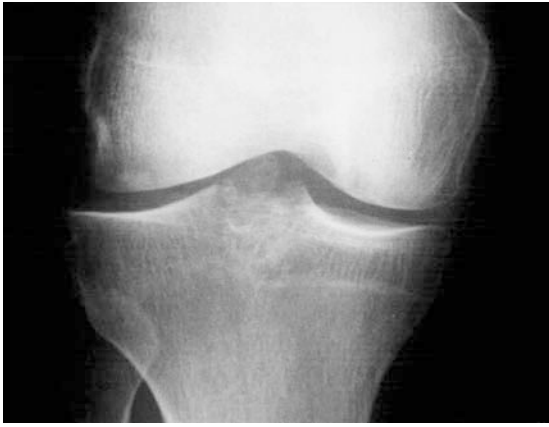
Plain radiograph of the right knee demonstrating narrowing of the joint space and juxta-articular osteoporosis
